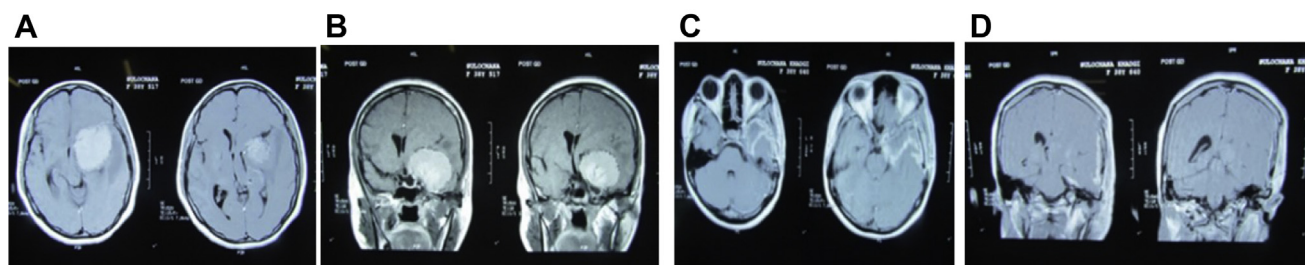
(A, B) Preoperative MRI of brain with IV contrast (axial and coronal, depicting large left clinoidal brilliantly enhancing meningioma with left carotid artery encasement by tumor. (C, D) Postoperative MRI of brain
